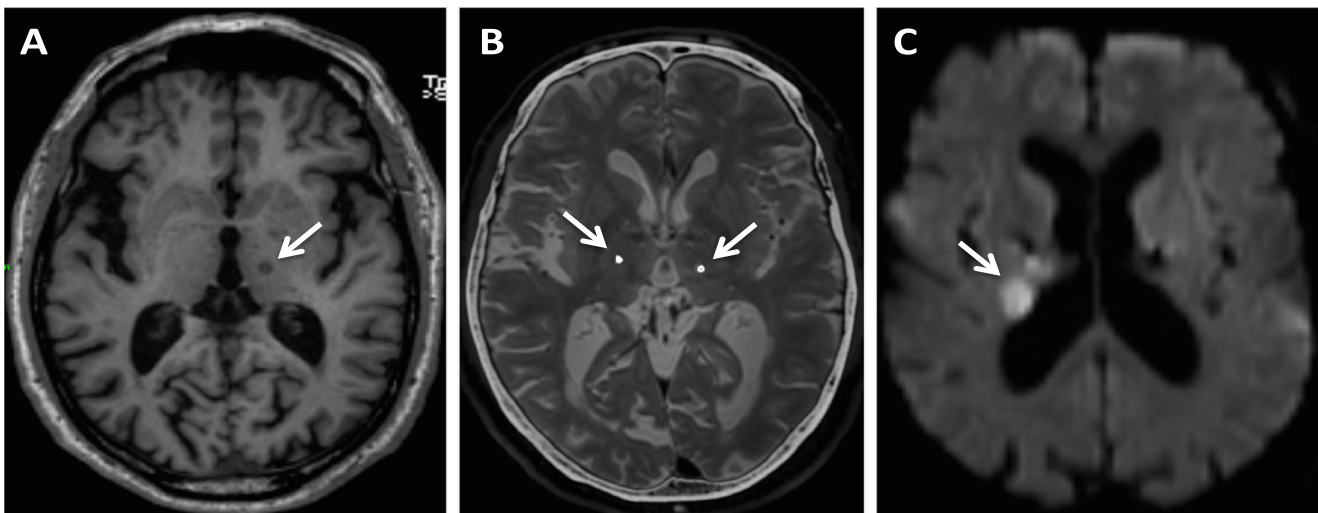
(A) T1w brain MRI, displaying the left thalamotomy (arrow). (B) T2w brain after the DBS procedure, with the tip of both electrodes (arrows). (C) Diffusion brain MRI, with the right anterior choroidal artery stroke (arrow)
